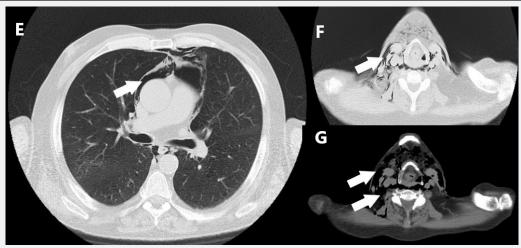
Coronal (E, F, G) cervicothorax CT scan: extensive pneumomediastinum and cervical subcutaneous emphysema (white arrows).
